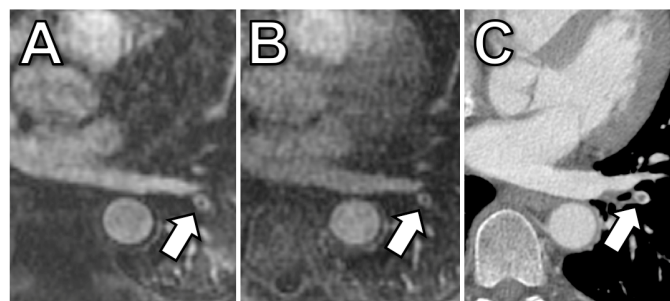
42-year old women with confirmed PE. First-pass MRA (A), steady state MRA (B) and corresponding CT (C). The central signal drop in a left lower lobe segmental pulmonary artery (arrow) corresponded to a true pulmonary embolus as confirmed by CT. Signal dropout was 57% at first-pass and 52% at steady state MRA. Of note, this embolus was the only one that was detected in this patient and may have easily been mistaken for a Gibbs artifact due to its central localization within the vessel and relatively small signal intensity drop.
